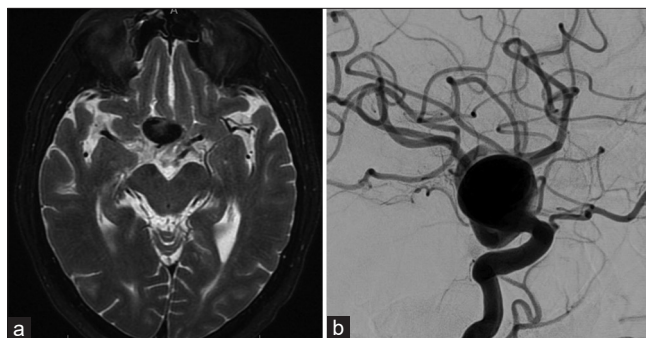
(a) Initial magnetic resonance imaging and (b) digital subtraction angiography demonstrated medially and superiorly projecting the right paraophthalmic aneurysm coming off just distal to the ophthalmic artery, compressing the optic chiasm.
